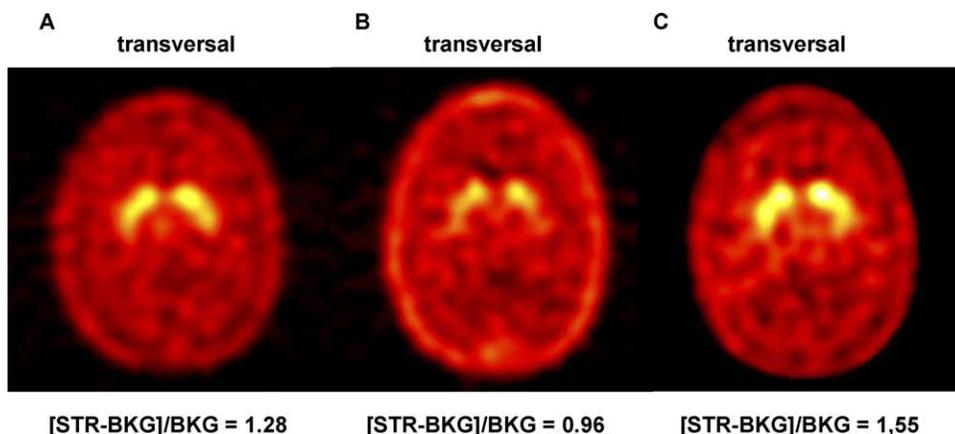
Dopamine transporter binding in the striatum of a 29 years old female smoker with ADHD before (A), after 4 weeks of intake of 3 × 5 mg methylphenidate (Ritalin®) per day (B), and 2 years later after 1 year of cessation of nicotine abuse and intake of methylphenidate, shown by specific accumulation of [<sup>123</sup>Tc-99m]TRODAT-1 in SPECT scans.
